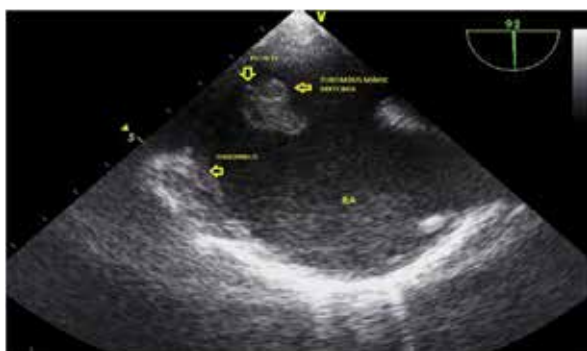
Transesophageal echocardiography (TOE) showed a pedunculated freely mobile mass.
